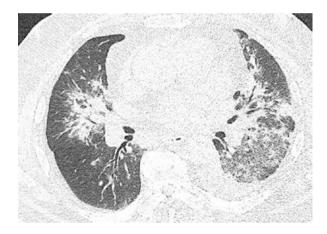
HRCT of the lung: Atoll sign—GGO surrounded with consolidation
